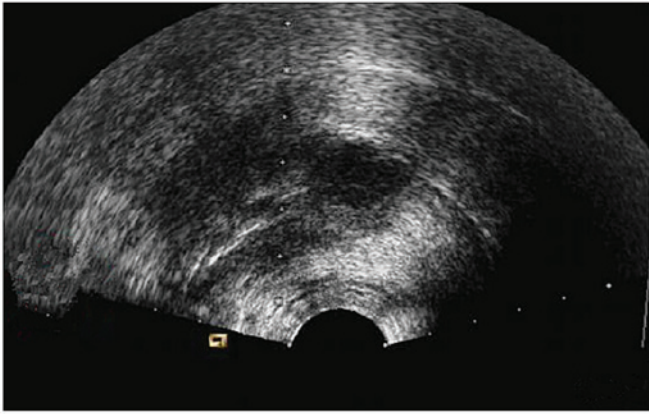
Post-operative ultrasound view showing no fibroids after the operation.
